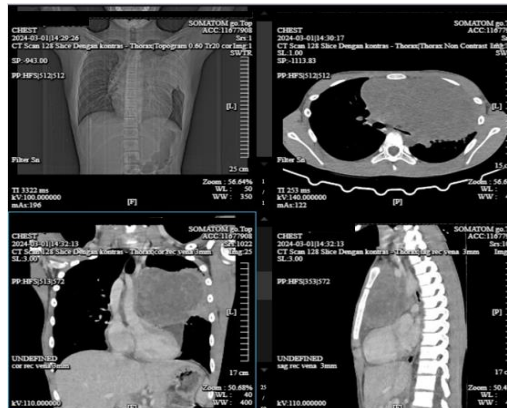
Preoperative CT-Scan found heterogenous solid mass with internal necrotic component on the anterosuperior mediastinum extending to right and predominantly left hemithorax with estimated size 17.8 x 9.6 . 9.8 cm³ attaching to bilateral parietal pleura. The mass caused deviation of the trachea, esophagus, and aorta to the right side, and narrowing of the left main bronchus. The imaging indicated malignant mediastinal mass on the anterosuperior compartment
